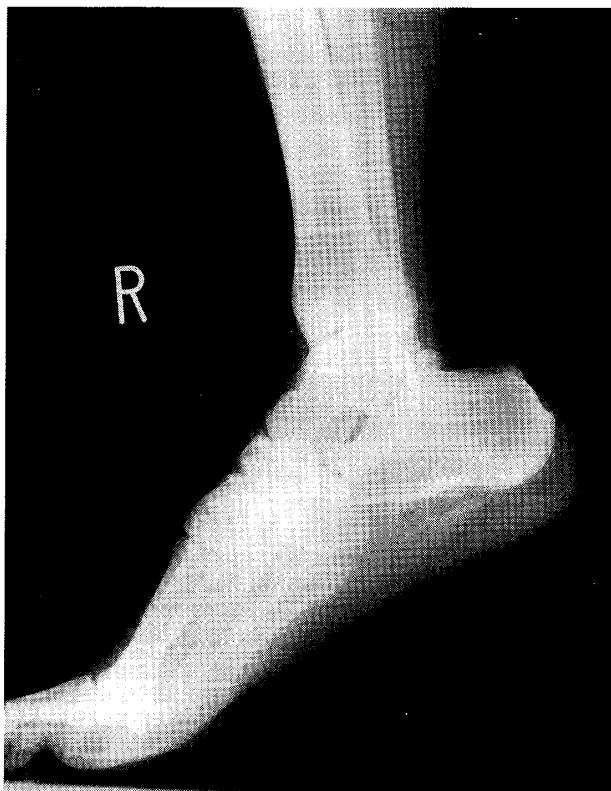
A roentgenogram of the right crus showed an image of grade 2 gas.
